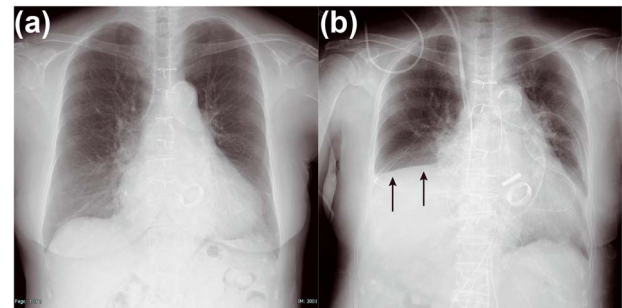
Chest radiographs. (a) Preoperative chest radiograph showing no elevation of the right diaphragm. (b) Chest radiograph on the second postoperative day showing elevation of the right diaphragm (black arrow).
